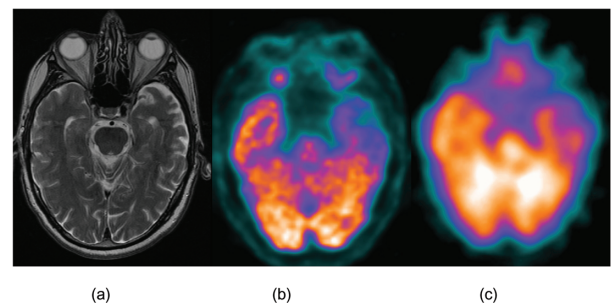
Imaging in patient 3 with primary progressive aphasia. (a) Magnetic resonance image showing left temporal lobe atrophy with corresponding abnormalities clearly visible on the (b) PET and (c) SPECT images.
